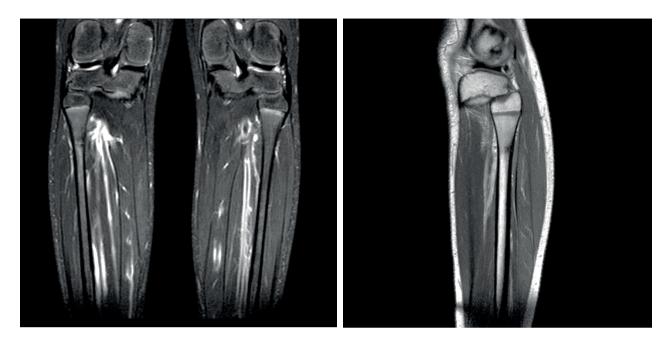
MRI views in healing phase and advanced edema resorption.
